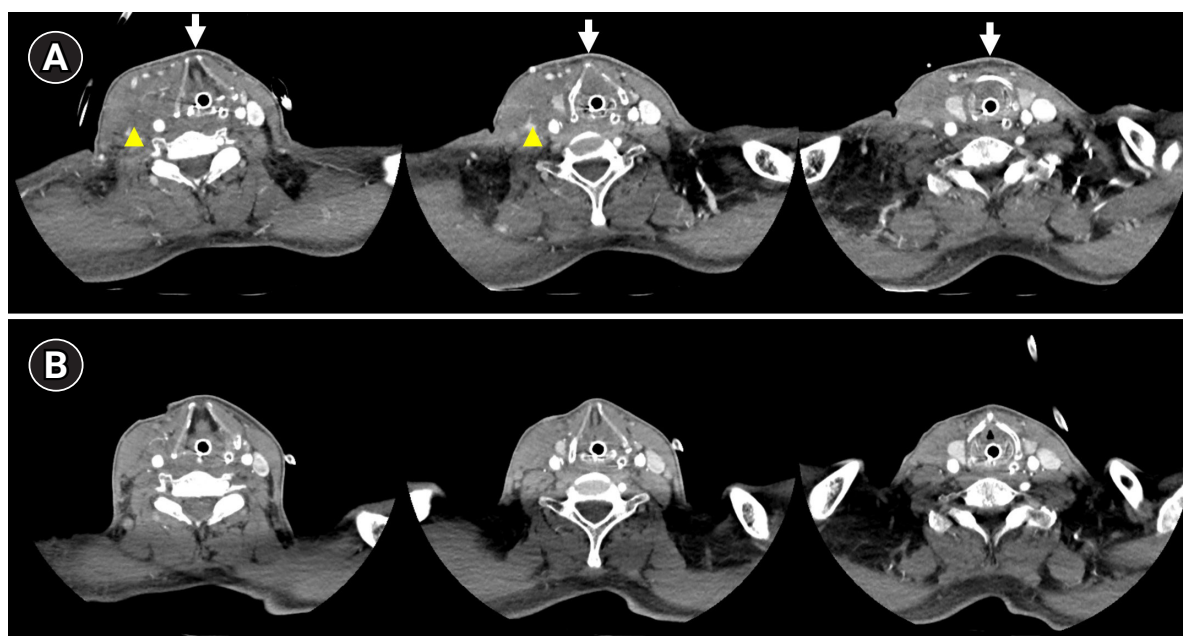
(A) Neck computed tomography (CT) taken after intubation shows tracheal deviation (white arrows) due to hematoma formation (yellow arrowheads) around the carotid vessels. (B) Neck CT taken 10 days later shows resorption of hematoma and improvement in tracheal deviation.
